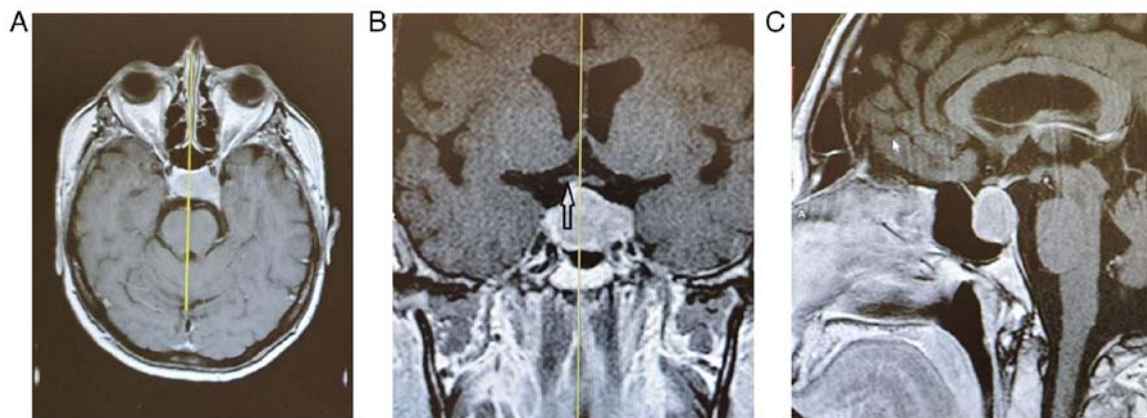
(A-C) Pre-operative contrast enhanced T1 MRI scan of patient 3, depicting a pituitary macroadenoma that comes into contact with, but does not compress the optic chiasma (arrow).
